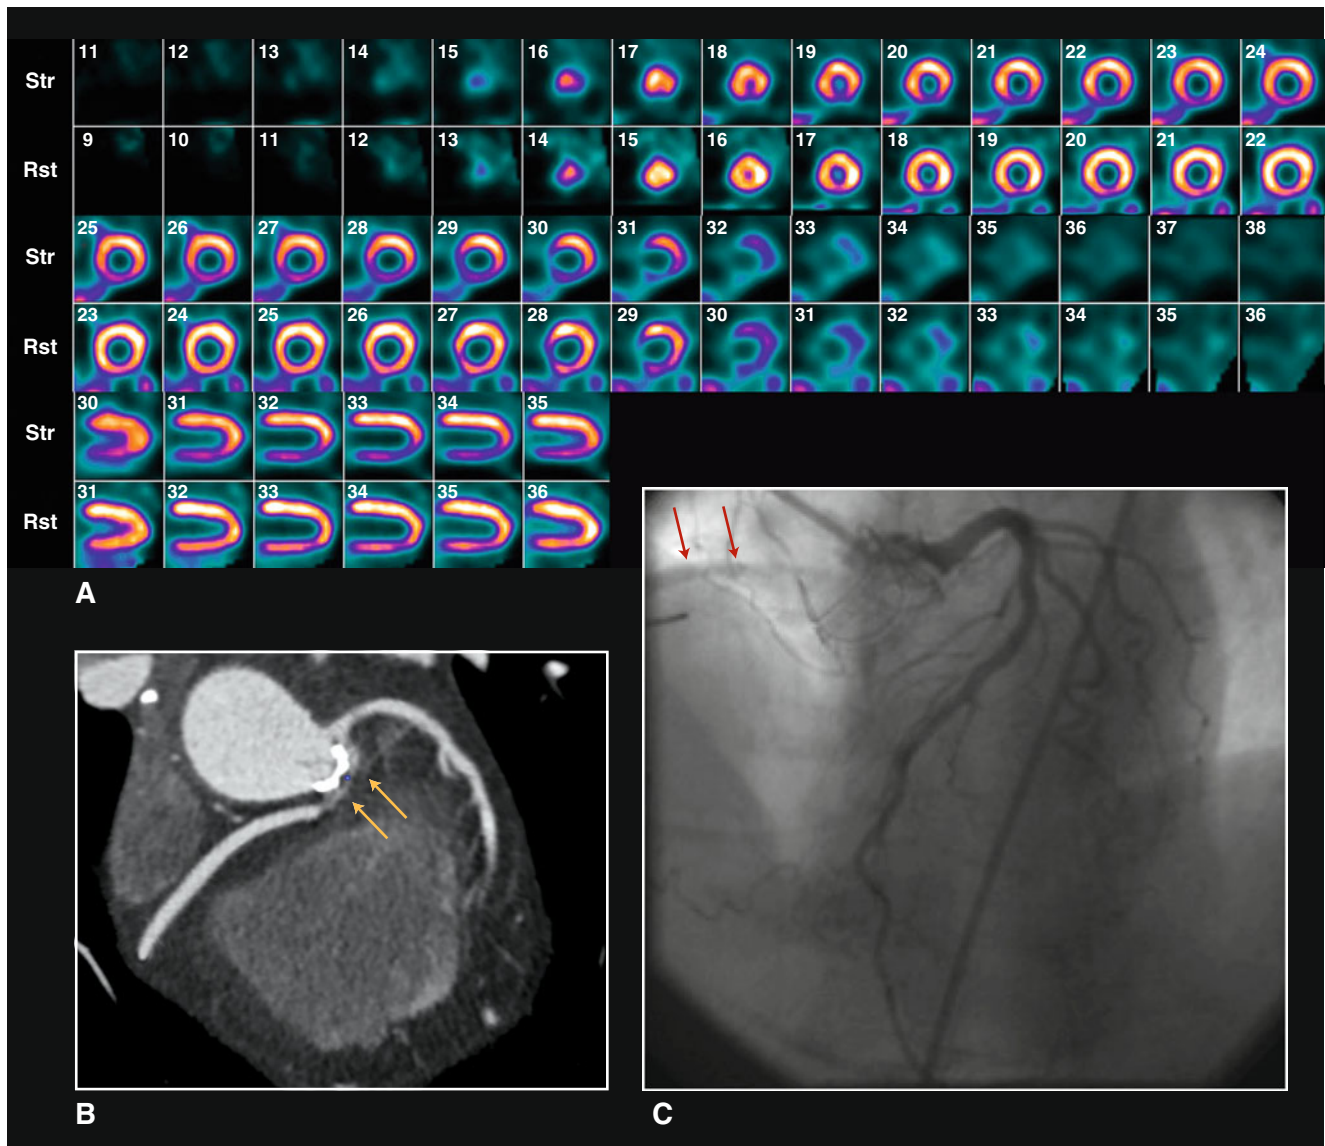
a–c, A 55-year-old woman with prior aortic valve replacement for bicuspid aortic valve presented with typical anginal symptoms 6 months after surgery. The stress myocardial perfusion scintigraphy (MPS) images (a) demonstrated a reversible perfusion defect in the inferior wall. Retrospective review of the preoperative invasive angiography (c) revealed faint contrast filling the right coronary artery
